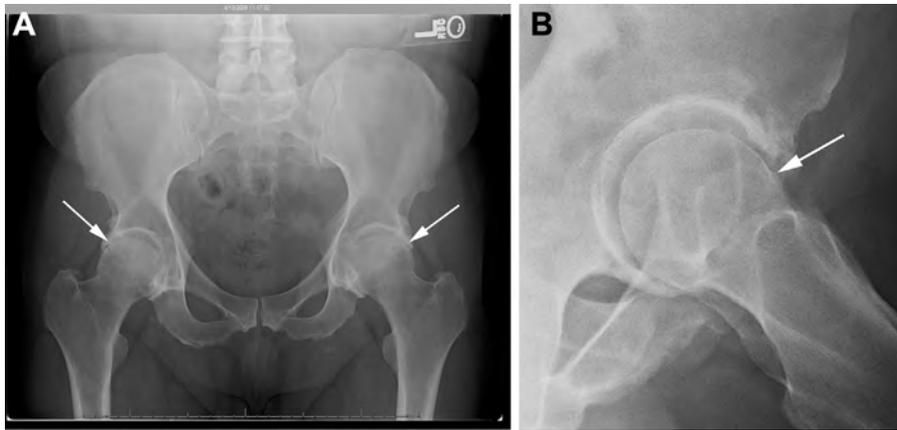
(A) A preoperative anteroposterior pelvis radiograph showed substantial acetabular overhang (arrows) with the appearance of lateral joint space narrowing, which was due to circumferential labral ossification. (B) A preoperative frog-lateral radiograph of the left hip showed extensive acetabular osteophytosis, a decreased femoral head/neck offset, and an aspherical femoral head anteriorly (arrow).
